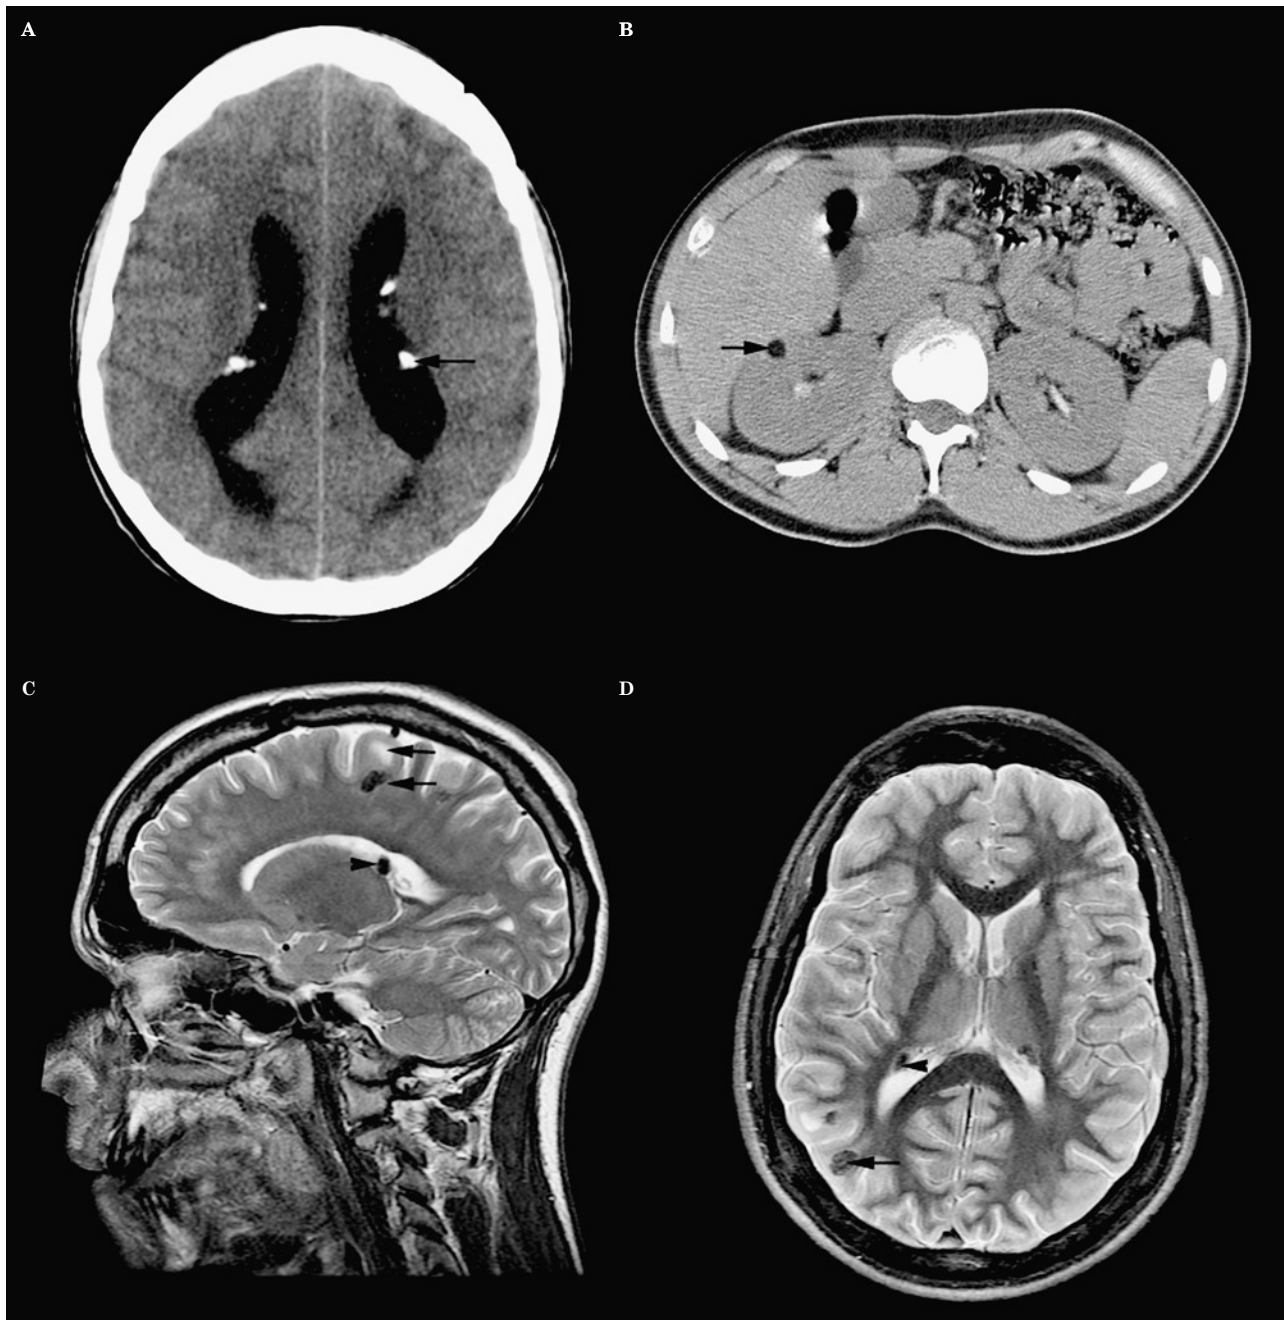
Tuberous sclerosis. A) Nonenhanced axial CT image shows characteristic subependymal calcifications (arrow) in both lateral ventricles. B) Abdominal CT scan demonstrates a well-defined fat containing lesion (arrow) in the right kidney, consistent with a renal angiomyolipoma. C) Sagittal T2W MR shows both high and low signal intensity white matter lesions (arrows) in the frontal lobe in keeping with subcortical tubers. A subependymal nodule (arrowhead) is also identified in the same image. D) Axial T2W MR image highlights the subcortical and subependymal tubers (arrows).
